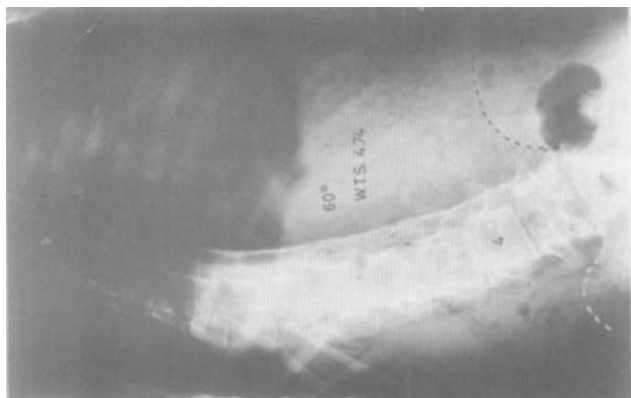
d. Antero-posterior radiograph of same patient four years after spinal fusion. Further loss of correction in the fused spine, the curve now measures 60°. Note the recurrence of the pelvic obliquity. Internal fixation was not possible because of soft bone and the thinness of overlying soft tissues.
